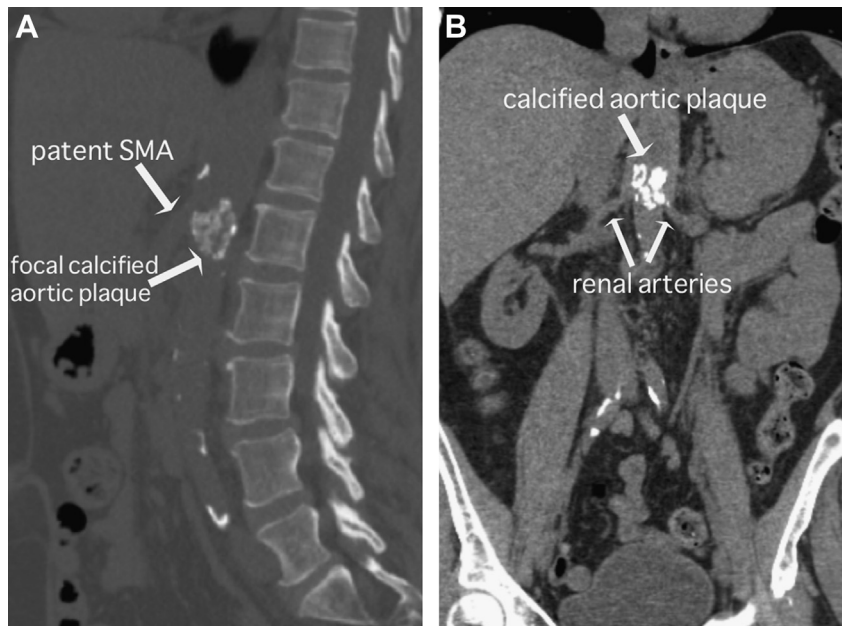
(A) A noncontrast abdominal computed tomography scan revealed a large coral reef–like calcified lesion in the pararenal aorta not affecting the superior mesenteric
